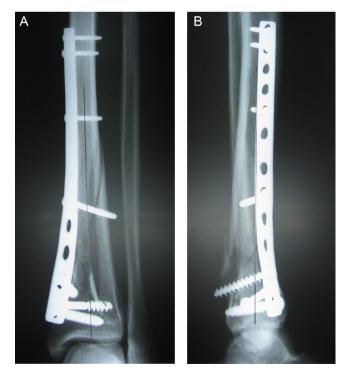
(A and B) A comminuted distal tibial fracture in a 55 year old man. This patient was treated with a non-locking plate DCP. Anteroposterior and lateral radiographs showing the correct alignment obtained with a DCP.
